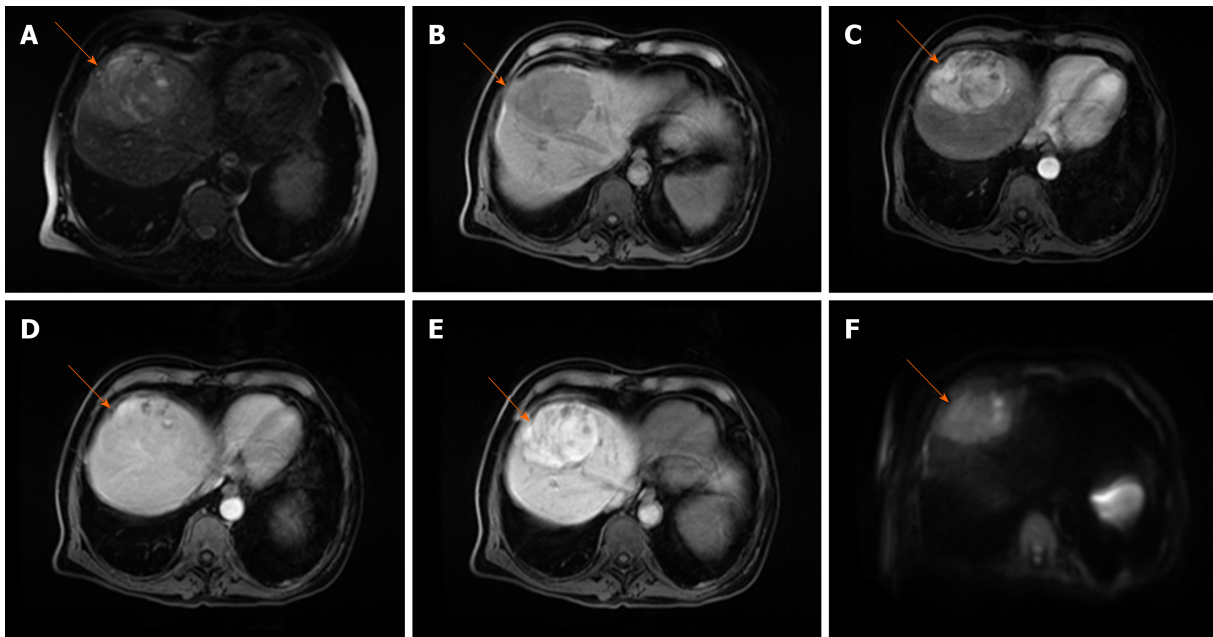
Hepatocellular carcinoma in 73-year old man with alcoholic cirrhosis. A: Axial T2-weighted fat-saturated image shows slightly hyperintense well-defined nodular lesion (arrow) in segment Iva; B-D: The lesion (arrow) is hypointense on T1-weighted FS image (B), hypervascular on arterial phase (C) without washout on portal-venous phase (D); E and F: On hepatobiliary phase the tumor is strongly hyperintense (E) with diffusion restriction on diffusion-weighted image (F).
